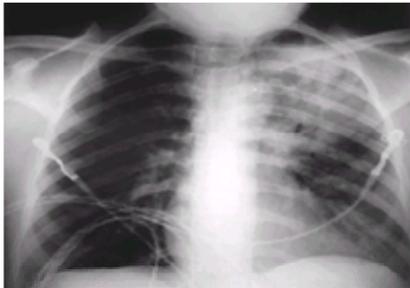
Posteroanterior chest x-ray film of case 2 reveals a left upper lobe infiltrate.
